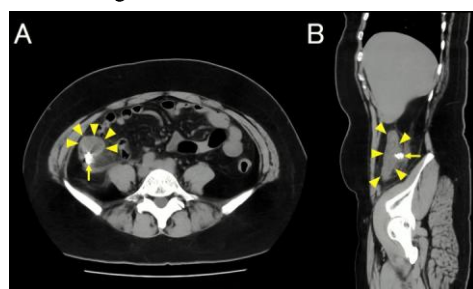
CT revealing ascending colon inflammation (arrowheads) with a very high CT value (arrows) (panel A: axial view and panel B: sagittal view) (reprinted with permission of the patient)
